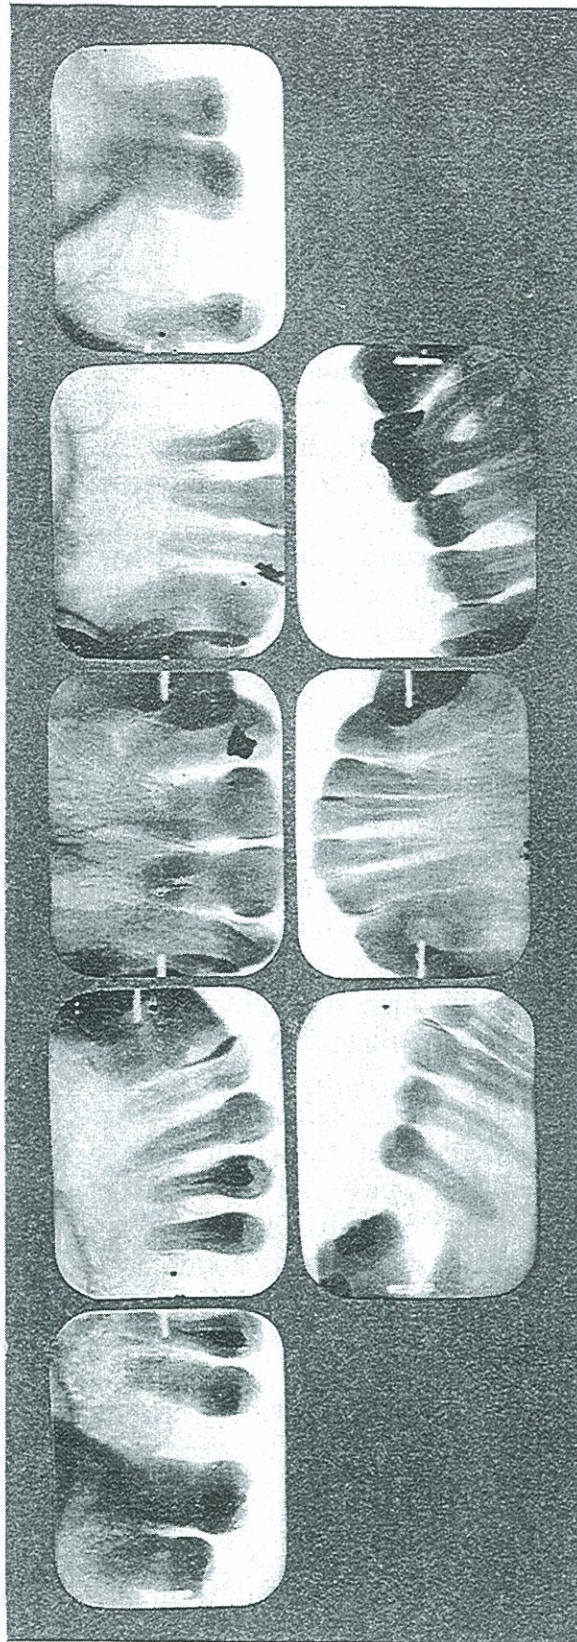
ROENTGENOGRAPHIC APPEARANCE OF TEETH OF CASE 1009, A SEVERELY SUFFERING INVALID WITH DEGENERATIVE ARTHRITIS. NOTE DIFFERENCE IN LOCAL STRUCTURAL CHANGE.
